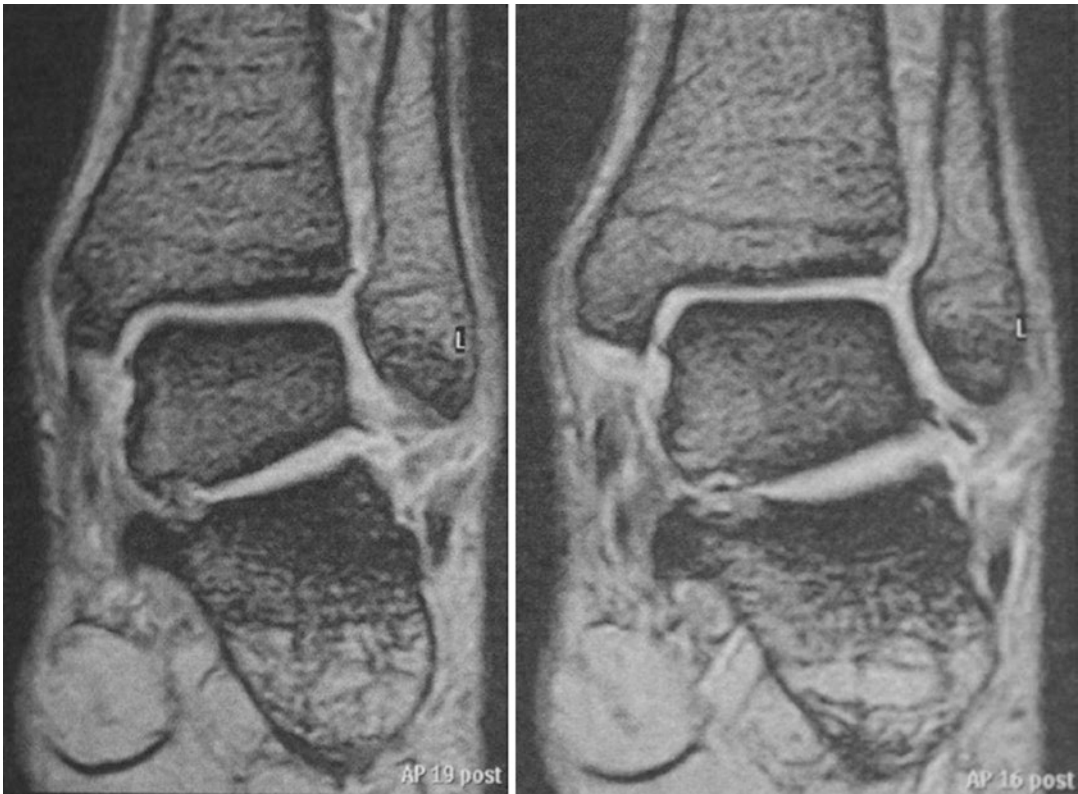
Magnetic resonance imaging of the left foot. It has visible signal changes in the lateral ligament complex (mainly in the CFL)
